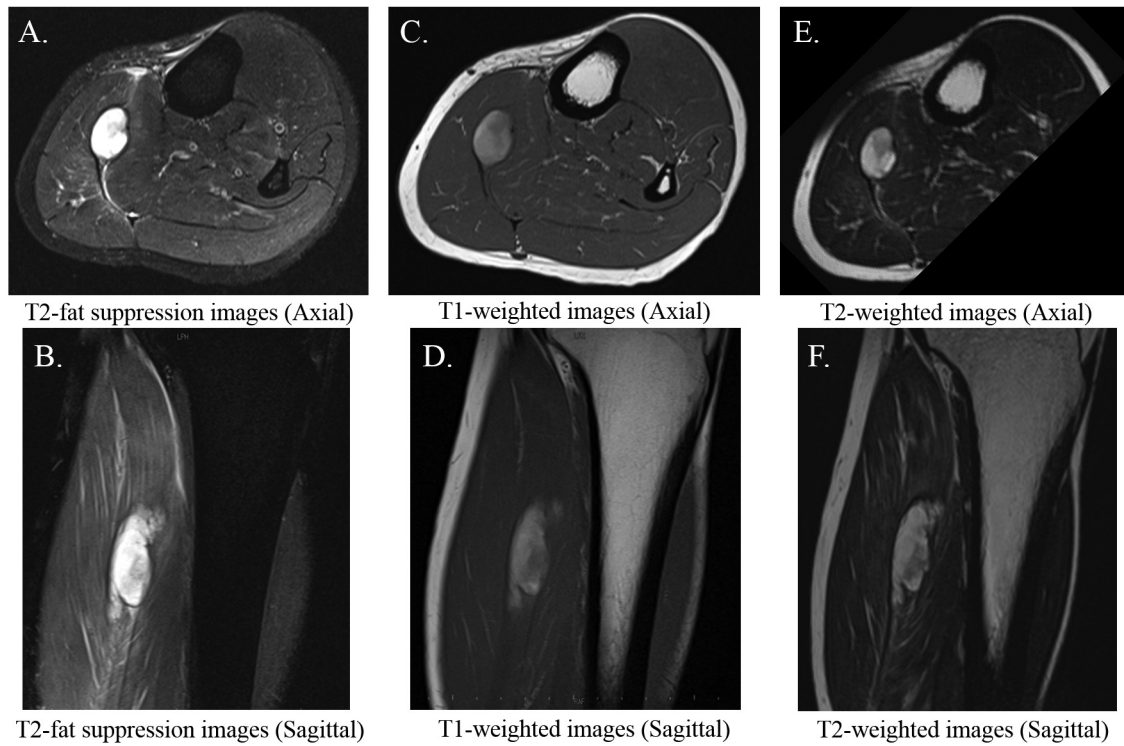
An axial view (A) and sagittal view (B) of T2-fat suppression magnetic resonance (MR) images. An axial view (C) and sagittal view (D) of T1-weighted MR images. An axial view (E) and sagittal view (F) of T2-weighted MR images.
